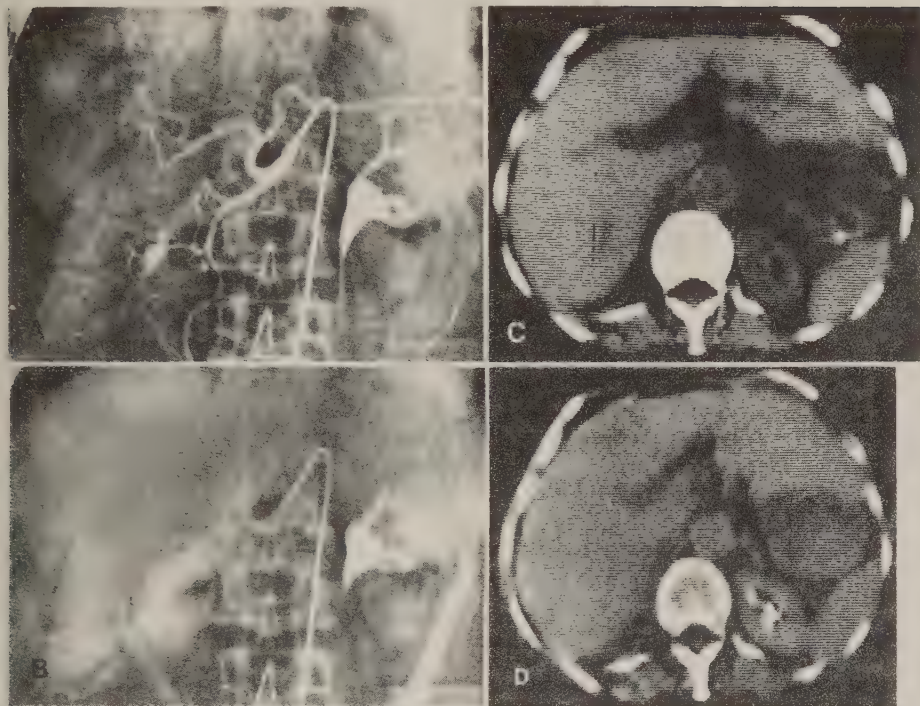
Fine nodular carcinoid metastasis. A Arterial; B parenchymal phase; C non-enhanced CT examination; and D contrast-enhanced CT examination. The area of slightly decreased attenuation seen anteriorly in the right lobe in C and D has too low a difference in attenuation (6 Hounsfield Unit) to be diagnostic for metastasis and in this case has been judged to be an artifact caused by rib-shadowing.
